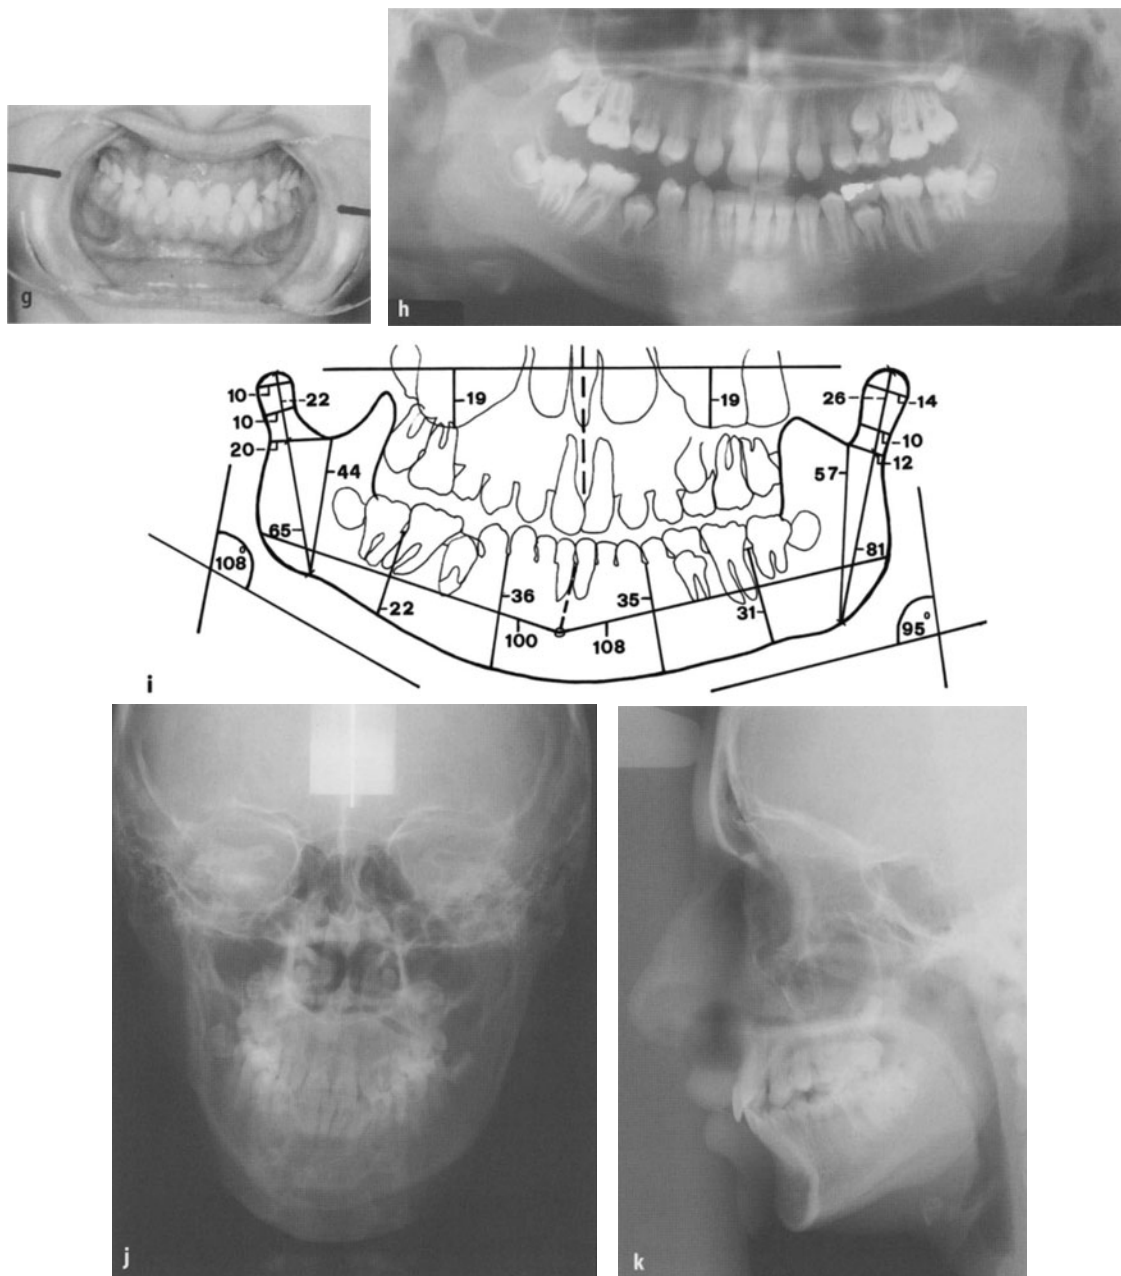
Case of unilateral congenital hypoplasia of the condyle. g The occlusion picture shows a shift of the mandible to the right side and an ascending occlusal plane towards the same side. h Panoramic radiograph of the mandible showing clear asymmetry between the right and left sides of the mandible with all the signs of a right side hypoplasia. i The measurement of the tracing of the panoramic radiograph gives clearer evidence of the degree of difference between left and right sides than expected by looking at the patient and her radiographs. j, k The p.a. projection cephalogram shows a more severe skeletal facial asymmetry than does the patient's front view (Fig. 16f). at the same age, while the lateral cephalogram discloses the vertical height discrepancy between the two bodies only
